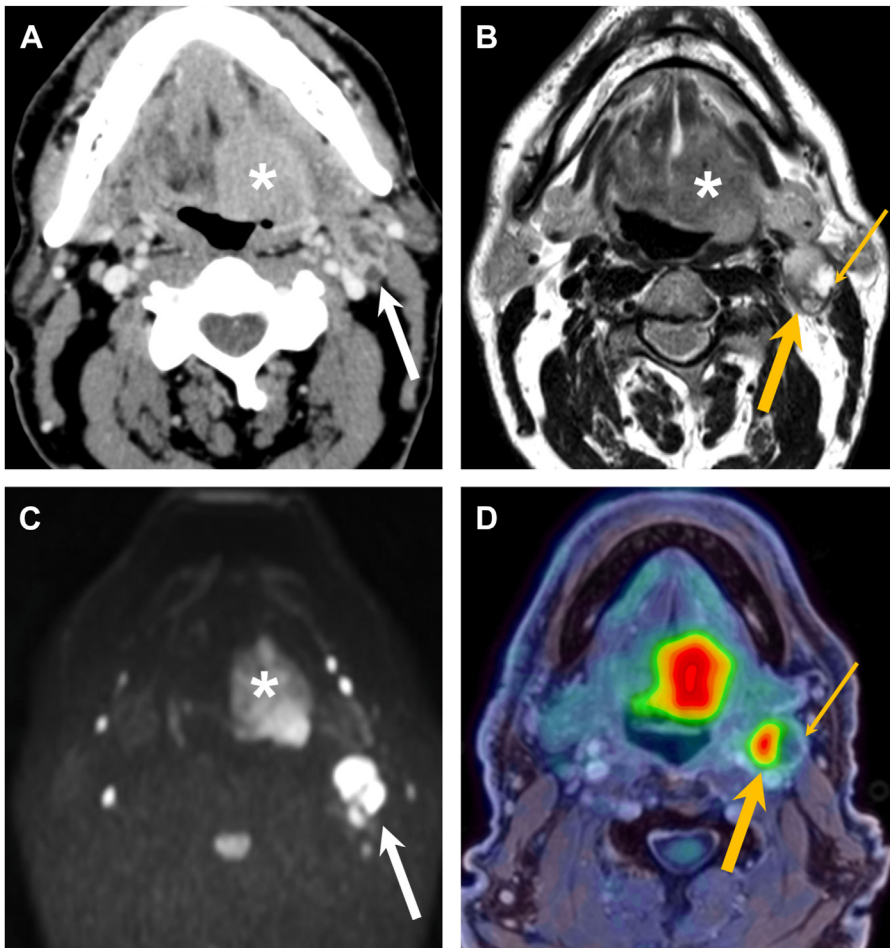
Characteristic aspect of metastatic lymph nodes on CT and PET/MR imaging. (A) Contrast-enhanced CT image obtained in a 58-year-old patient with an HPV positive base of the tongue SCC (asterisk). Note an ipsilateral enlarged level II metastatic node (arrow) with peripheral rim enhancement and necrotic portions. Corresponding PET/MR imaging obtained at the same level (B). T2W image (C) b 1000 image from DWI. (D) Fused PET and contrast-enhanced Dixon image. The tumor (asterisks in B and C) invades the extrinsic tongue muscles and has an intermediate signal intensity on T2, restricted diffusion and increased FDG uptake ($SUV_{max} = 15$). The solid portions of the level II metastatic node (thick yellow arrows) show increased FDG uptake ($SUV_{max} = 14$), whereas the necrotic portions (thin arrows) show no relevant uptake.
